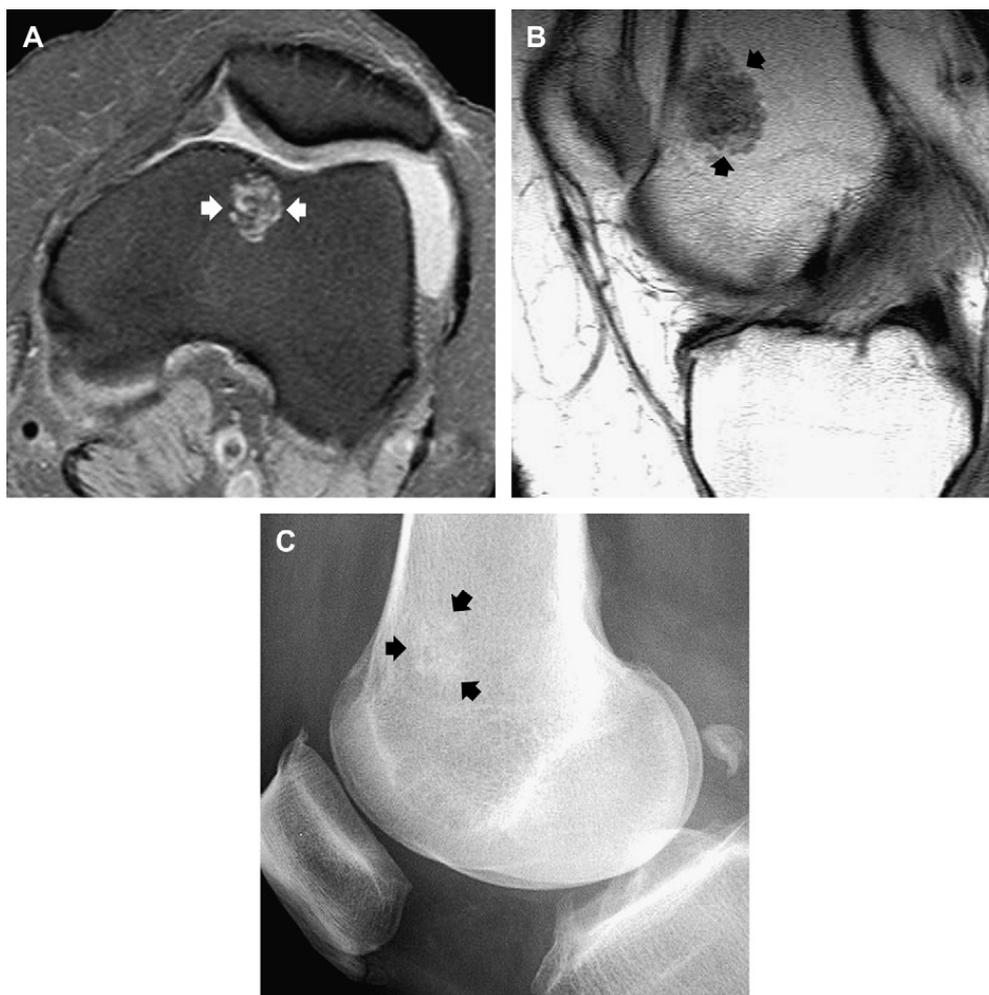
Incidental enchondroma in the distal femoral metaphysis of a 68-year-old woman. (A) Axial fat-suppressed proton density (TR/TE; 2200/22) fast spin-echo MR image shows a well-defined eccentric lesion (arrows). The lesion abuts but does not scallop the cortex. (B) Sagittal proton density (TR/TE; 2000/20) fast spin-echo MR image shows the lobular contour to better advantage, as well as curvilinear regions of fatty marrow interdigitating between the cartilage lobules (arrows). (C) Corresponding lateral radiograph shows the subtle mineralization within the lesion (arrows).
